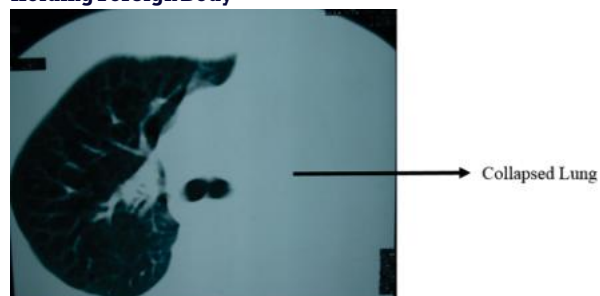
CT Scan of Thorax with Completely Collapsed Lung (Opacity Due to Foreign Body Occluding the Left Main Bronchus).
